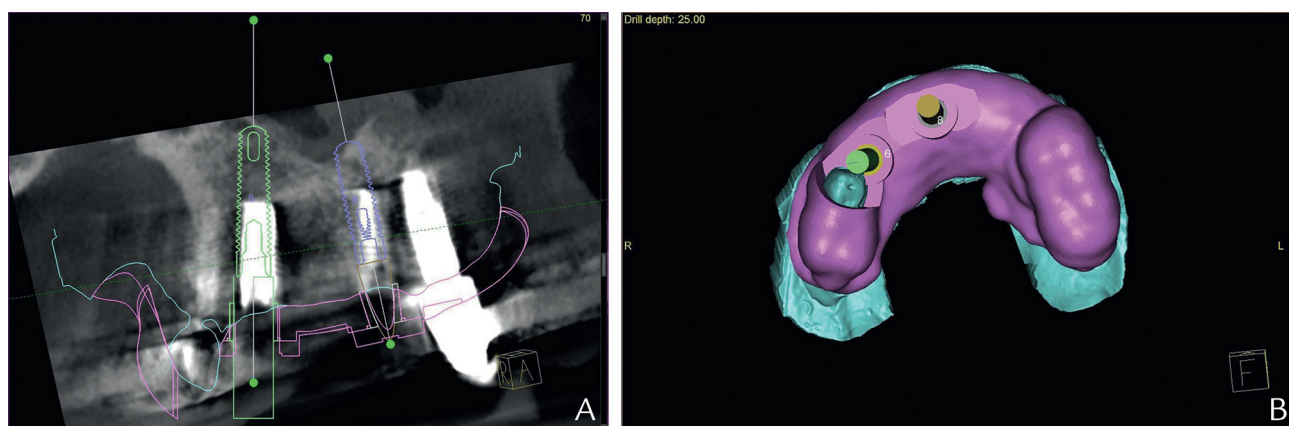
Planning implant placement guide. A, Two longer and smaller diameter replacement implants planned (CBCT scan). B, Implants planned to be placed slightly palatal to original sites to facilitate grafting and facial bone regeneration (3-dimensional design based on CBCT scan).
